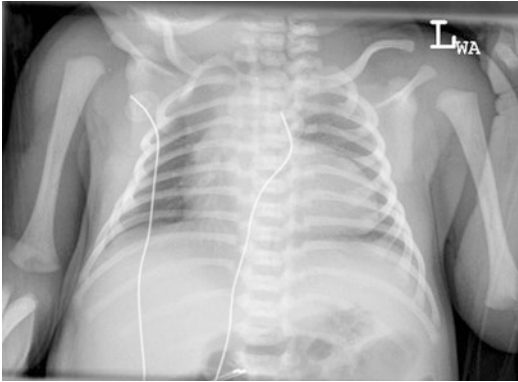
Chest radiograph of a child with uncorrected tetralogy of Fallot. Note the rounded left heart border and uplifted cardiac apex, giving the appearance of a “boot shaped” heart
